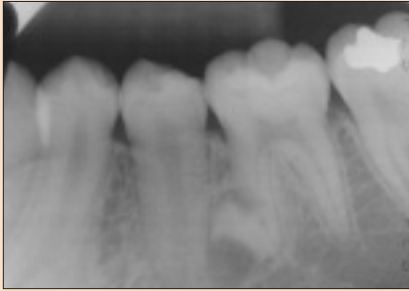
Periapical radiograph of tooth 35 shows the presence of a supernumerary premolar.
